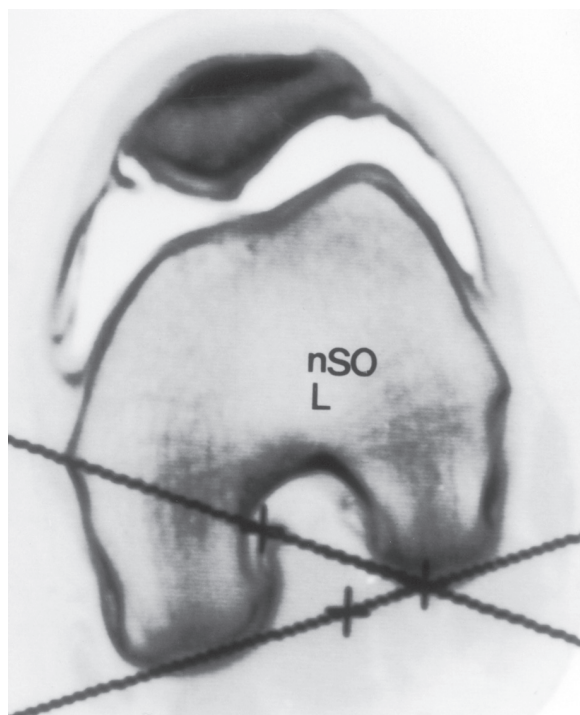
CT arthrogram. Loss lateral articular cartilage, shallow trochlea, post lateral release and arthroscopic chondroplasty
